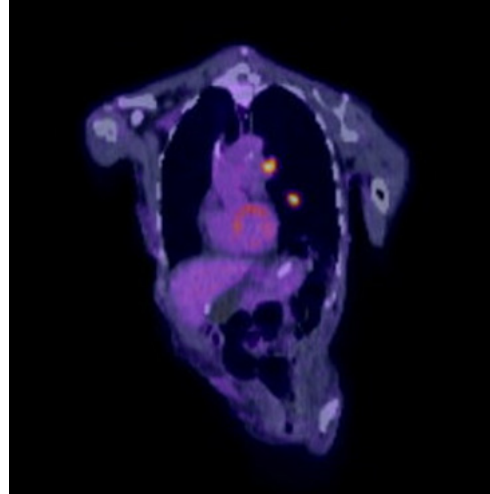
Whole Body Pet demonstrating FDG uptake in 2 lung nodules.
